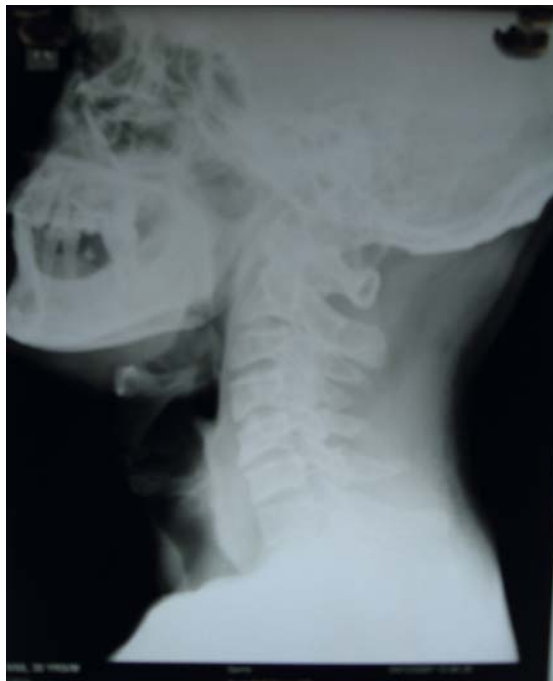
X-ray neck lateral view- showing no space to pass Endotracheal tube
